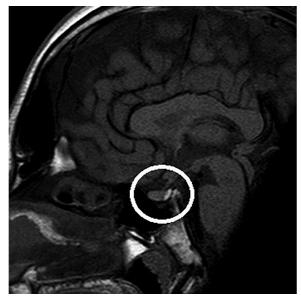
MRI of the pituitary gland, sagittal plane, revealed normal radiology findings of the pituitary gland (white circle).*
